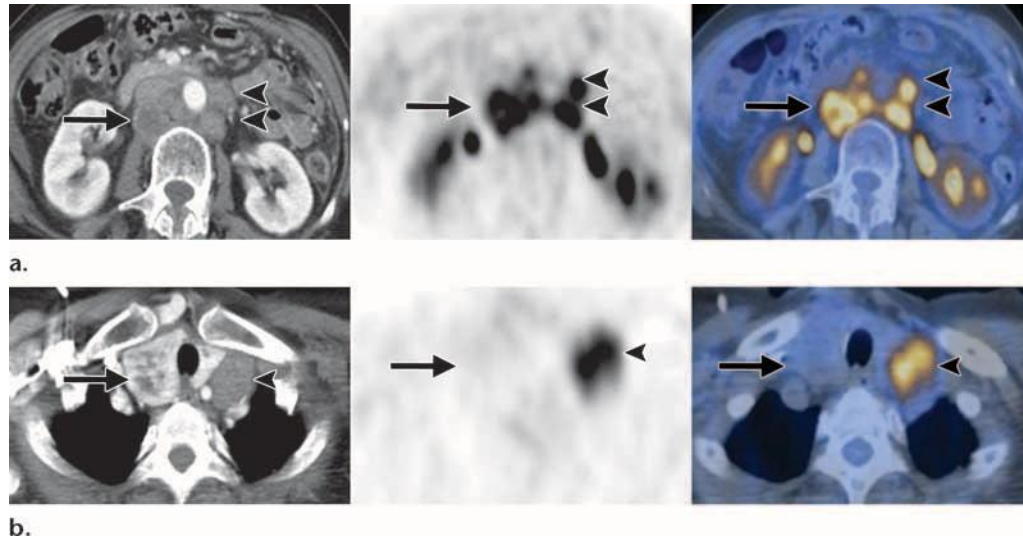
Lymph node metastasis in a 59-year-old woman with gradually rising CA-125 levels who underwent chemotherapy for stage IV ovarian cancer. (a) Axial contrast-enhanced CT (left), FDG PET (middle), and fused PET/CT (right) images show multiple enlarged paraaortic (arrowheads), aortocaval, and retrocaval (arrow) lymph nodes, all of which demonstrate markedly increased FDG uptake, a finding indicative of metastatic nodal disease. An enlarged retrocaval node with a photopenic center is noted at PET/CT, a finding that corresponds to the area of necrosis seen at CT. (b) Axial contrast-enhanced CT (left), FDG PET (middle), and fused PET/CT (right) images, obtained at the level of the upper thorax, show a large hypermetabolic left supraclavicular, superior mediastinal lymph node (arrowhead) compressing the left lobe of the thyroid gland, a finding indicative of distant metastatic disease. Note the enlarged and heterogeneously enhancing, nonhypermetabolic right thyroid lobe (arrow), a finding that likely is consistent with multinodular goiter.
